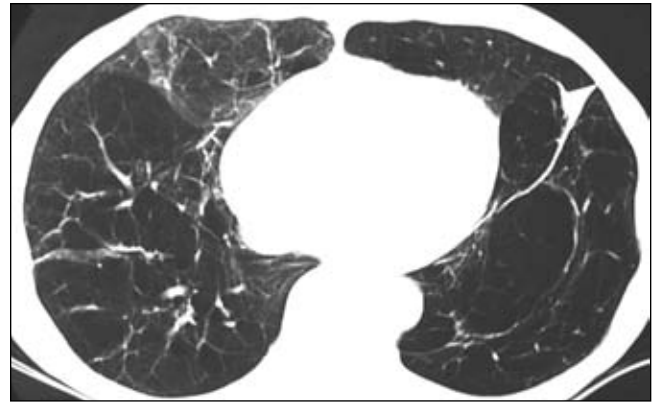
Computed tomography scan of the lower lung fields showing extensive emphysematous changes
